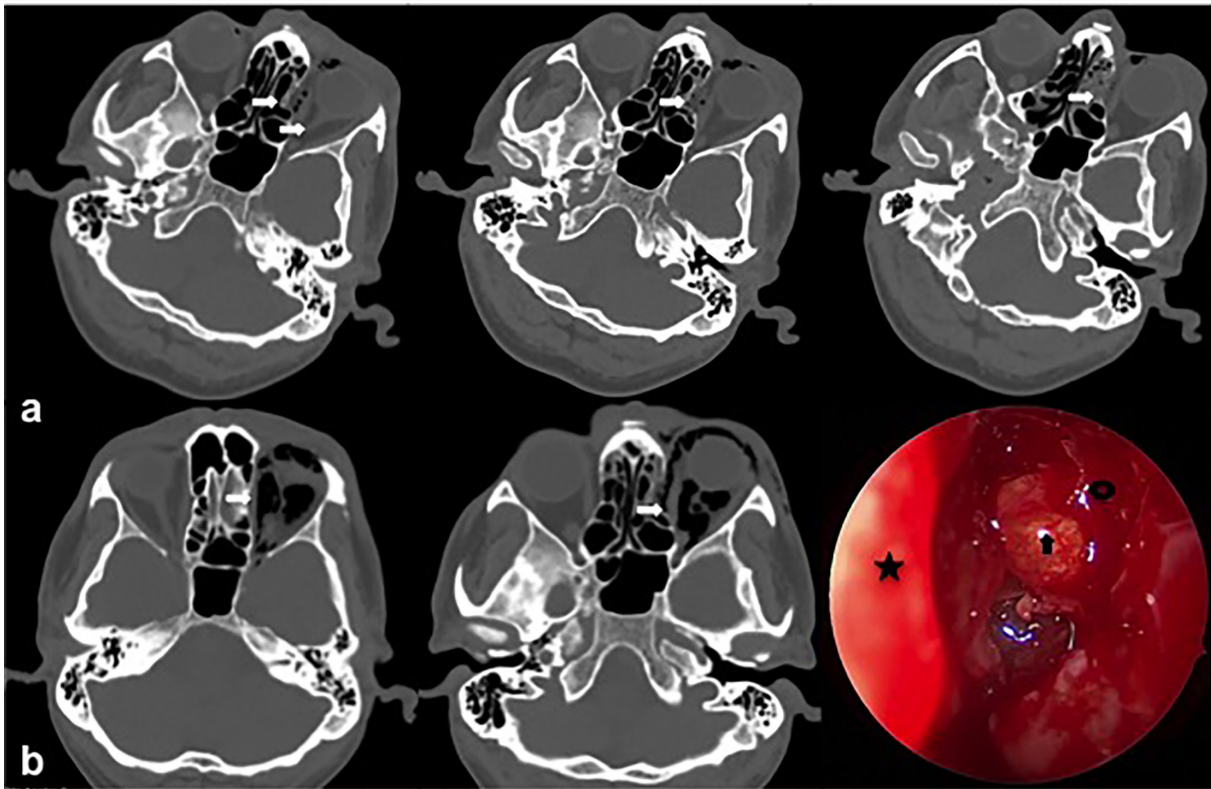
a,b. (a) Axial sections of initial maxillofacial CT scan indicate slightly depressed left orbital medial wall (white arrow) and minimal air. (b) Axial sections show pneumo-orbit and intraoperative endoscopic view of sinonasal cavity showing nasal septum (★), fracture in lamina papyracea (○), and protruding fat (é).
